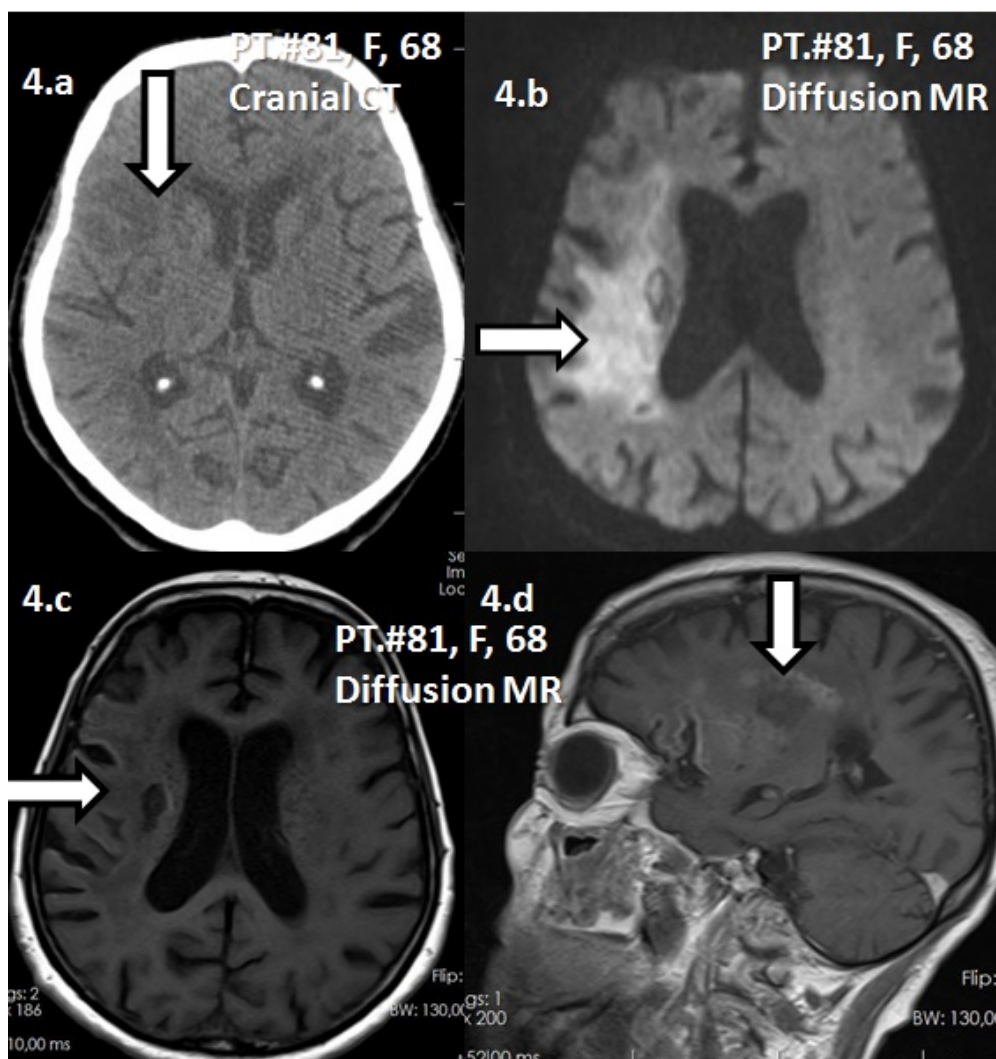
In Pt.#81, 68 years old, female patient treated with total knee arthroplasty, (a) cerebrovascular embolism in right middle serebral artery in cranial CT and (b-d) diffusion MR images.
